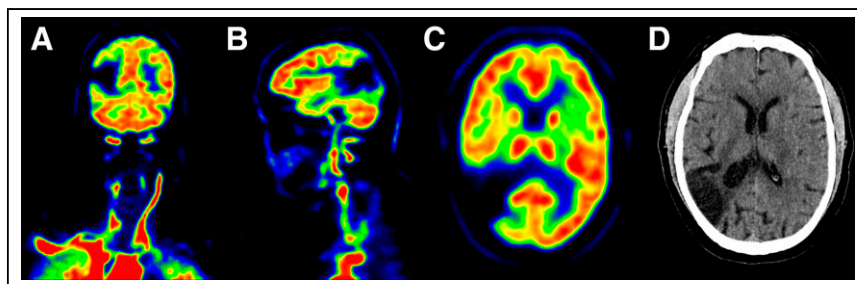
Brain infarction in parietooccipital watershed area detected by total-body perfusion PET: coronal PET slice (A), sagittal PET slice (B), transaxial PET slice (C), and transaxial corresponding CT image confirming brain infarction (D). Images are summed PET images of all frames of dynamic scan.
